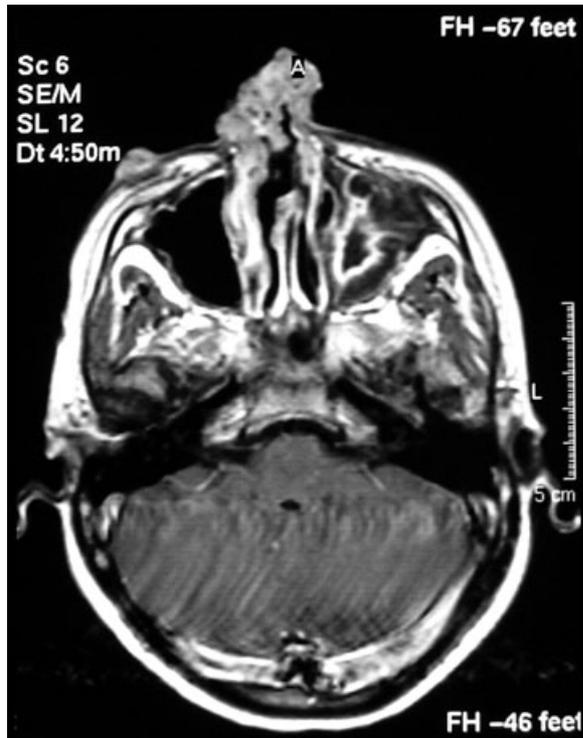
Infiltrates of paranasal sinuses demonstrated with magnetic resonance imaging (MRI) scan.
